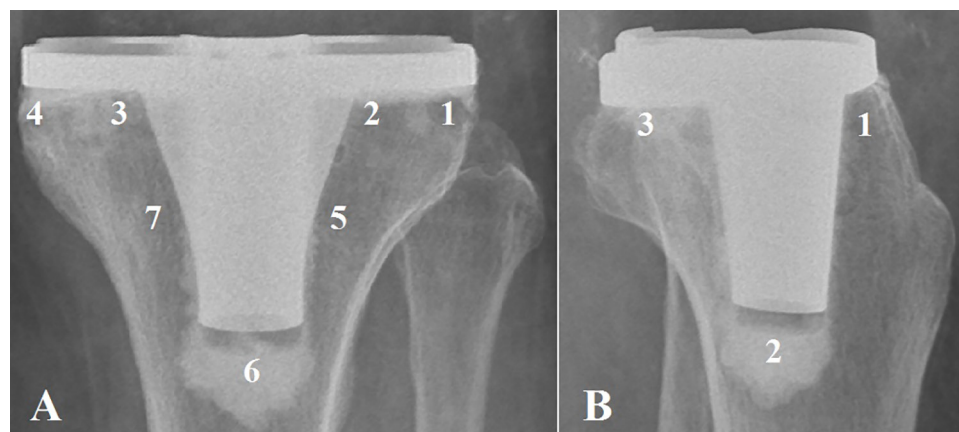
The zones adjacent to the tibial component in the anteroposterior (A) and lateral (B) radiographs for the knee society radiographic evaluation system.
